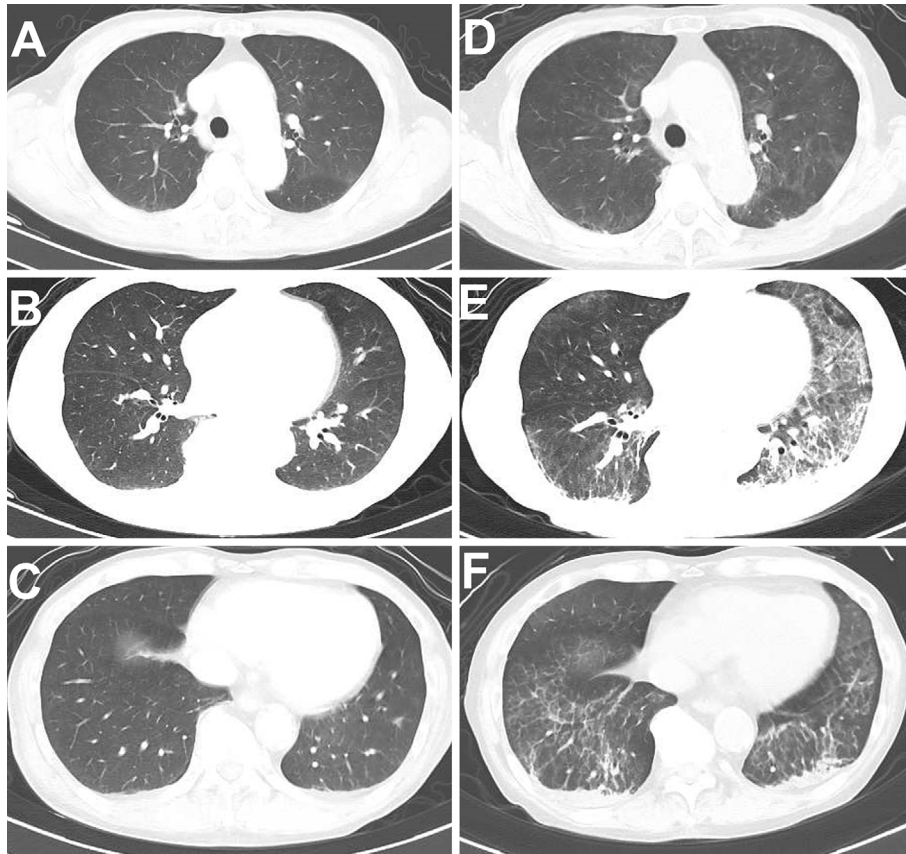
(A-C) Chest CT image obtained at the time of the idiopathic inflammatory myopathy diagnosis (January 2021). (D-F) Chest CT image obtained on admission (September 2021). CT: computed tomography
